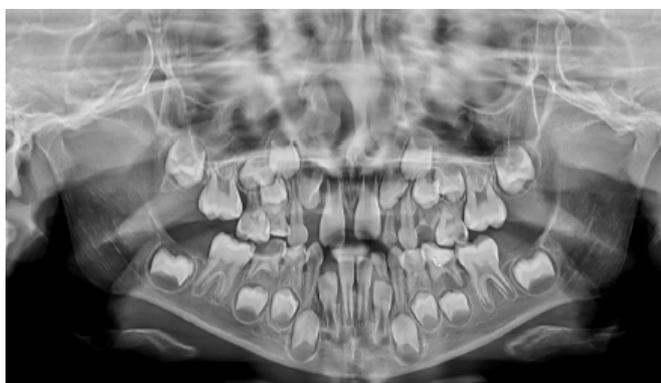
Orthopantomography of patient
